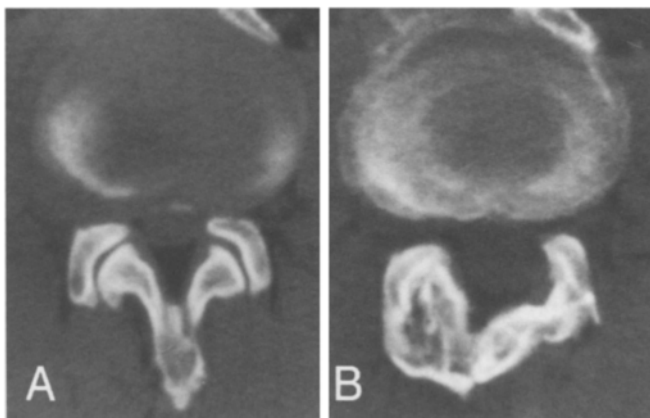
CT appearance in a patient who underwent expansive laminoplasty. A Preoperative CT: degenerative spinal stenosis at the central and lateral canal is demonstrated. B Postoperative CT: spinal canal is enlarged into a rectangular shape; bilateral facet joints are completely fused
